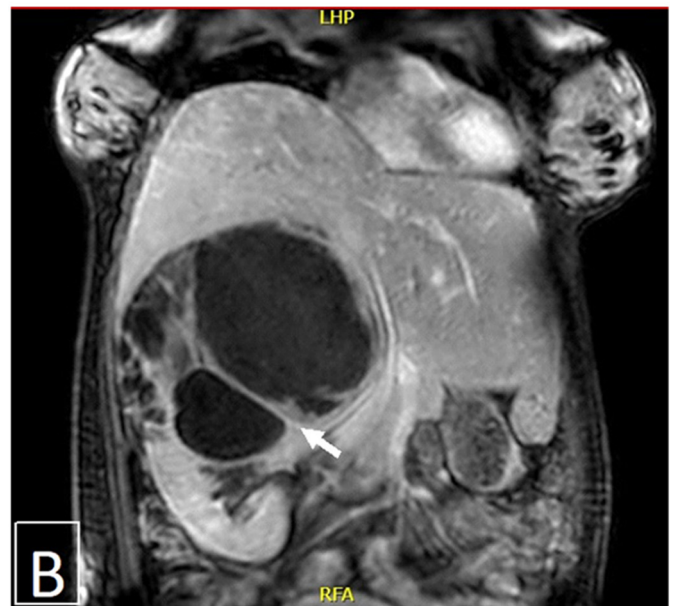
Magnetic Resonance Image of the abdomen and pelvis with 1.5 T field strength post 20 ml of Dotarem administered intravenously. A: coronal T2W images of the abdomen and pelvis revealing a large multiloculated and multiseptated cystic mass arising from the upper pole of the right kidney, measuring $19 \times 15.5 \times 16.5$ cm in its transverse, AP and craniocaudal dimensions, respectively. The mass is abutting the right hepatic lobe with no definite infiltration. It exerts mass effect on adjacent structures including the aorta, celiac trunk, portal confluence, gallbladder and the pancreas, which are deviated to the left side. There is right perinephric fat stranding and edema. B: T1W coronal image during venous phase showing a large multicystic lesion arising from the upper lobe of the right kidney with wall and septal enhancement post contrast administration. The cysts do not show any solid enhancement or component.
